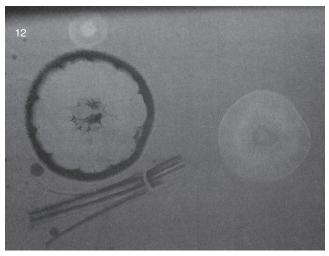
Radiographs of an orange, kiwi, piece of celery, and chunk of carrot show the effects of subtle differences in mass density. (Courtesy Marcy Barnes, Lexington Community College.)
